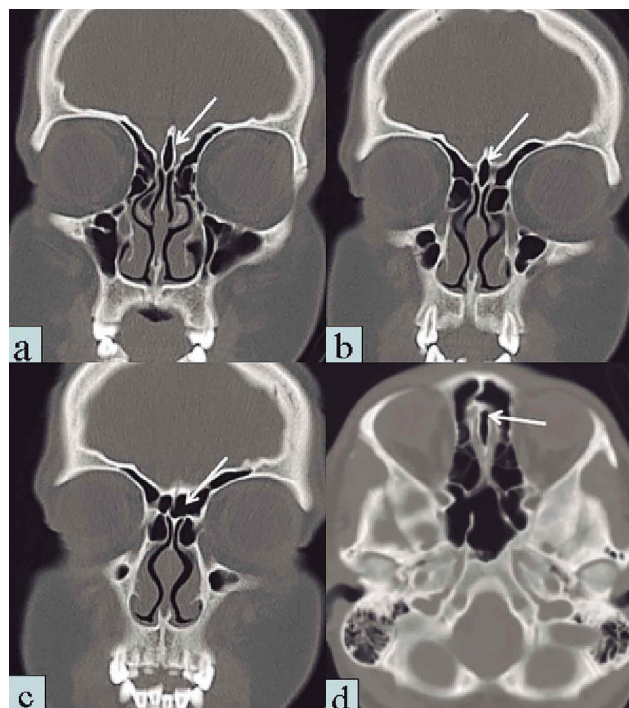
Paranasal CT images from a 17-year-old patient. a, b, c: CGP in the coronal plane and its communication with the left frontal sinus. d: In the same patient, CGP in the axial plane and its communication with the left frontal sinus.
